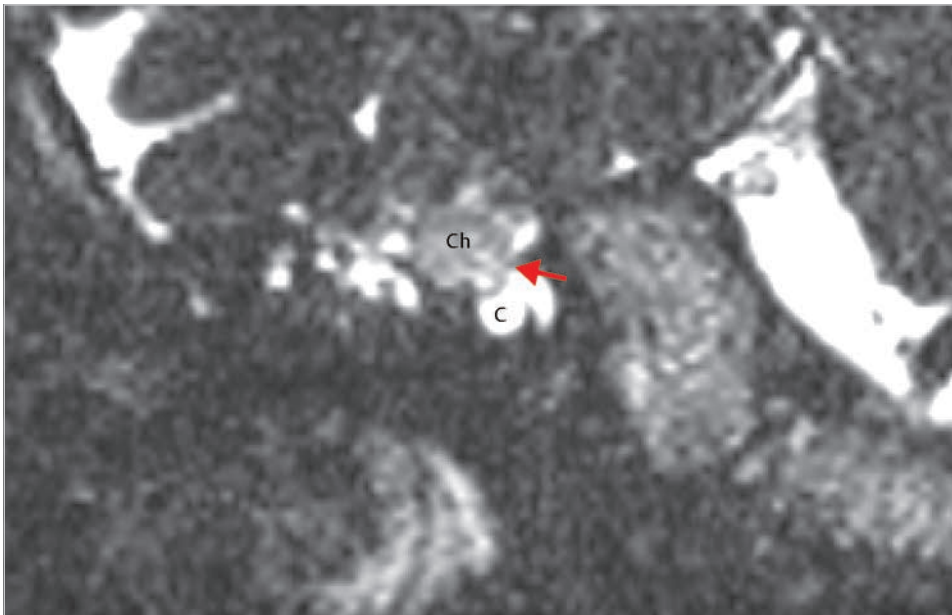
The coronal image of preoperative MRI of heavily T2-weighted image demonstrates cochlear infiltration (*arrow*) by the cholesteatoma. C, cochlea; Ch, cholesteatoma.
